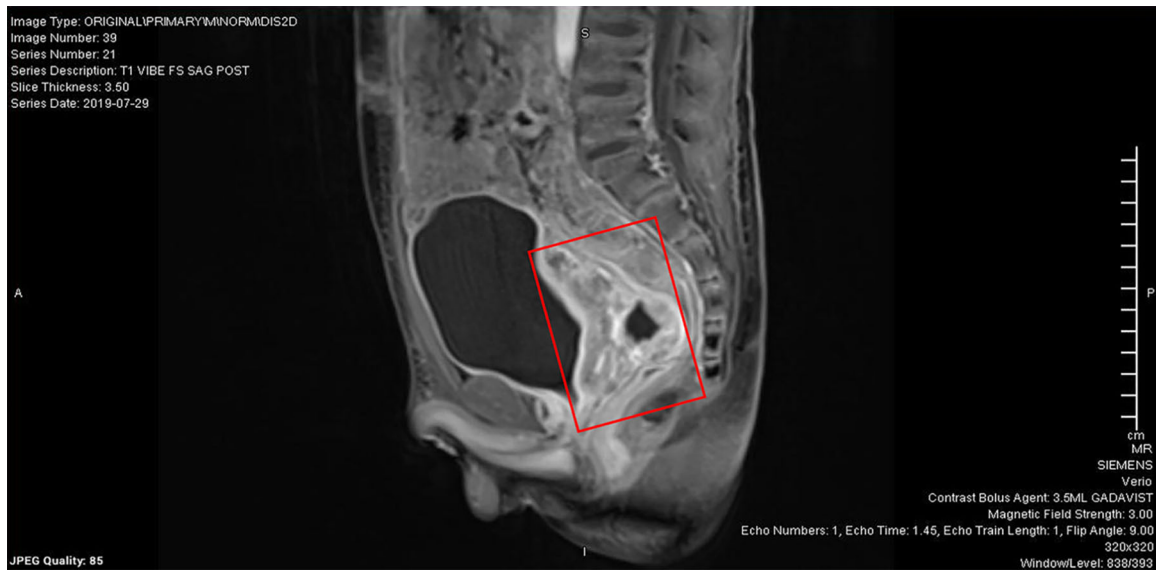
A sagittal view of the mass on pelvic MRI with contrast revealing compression of the rectosigmoid colon. MRI, magnetic resonance imaging.
